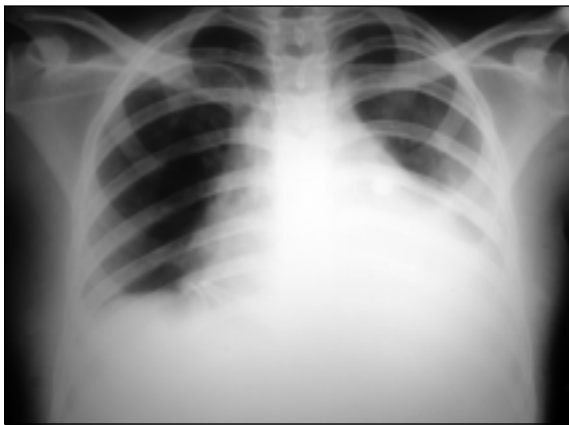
Chest X-ray revealing bilateral pneumonia, right pleural effusion and pericardial effusion
